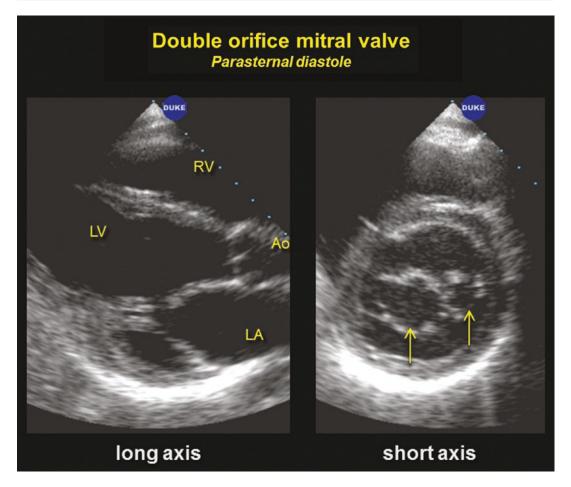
Parasternal long and short axis from a patient with a double orifice mitral valve (arrows, right panel)
